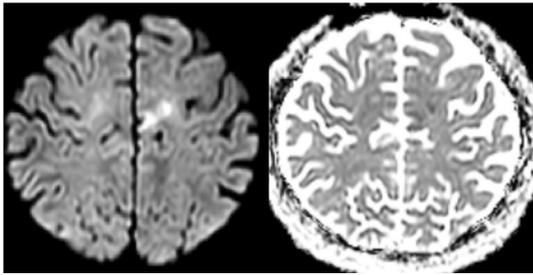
Diffusion weighted imaging MRI showing a small acute infarction in left anterior cerebral artery territory corresponding to SMA
